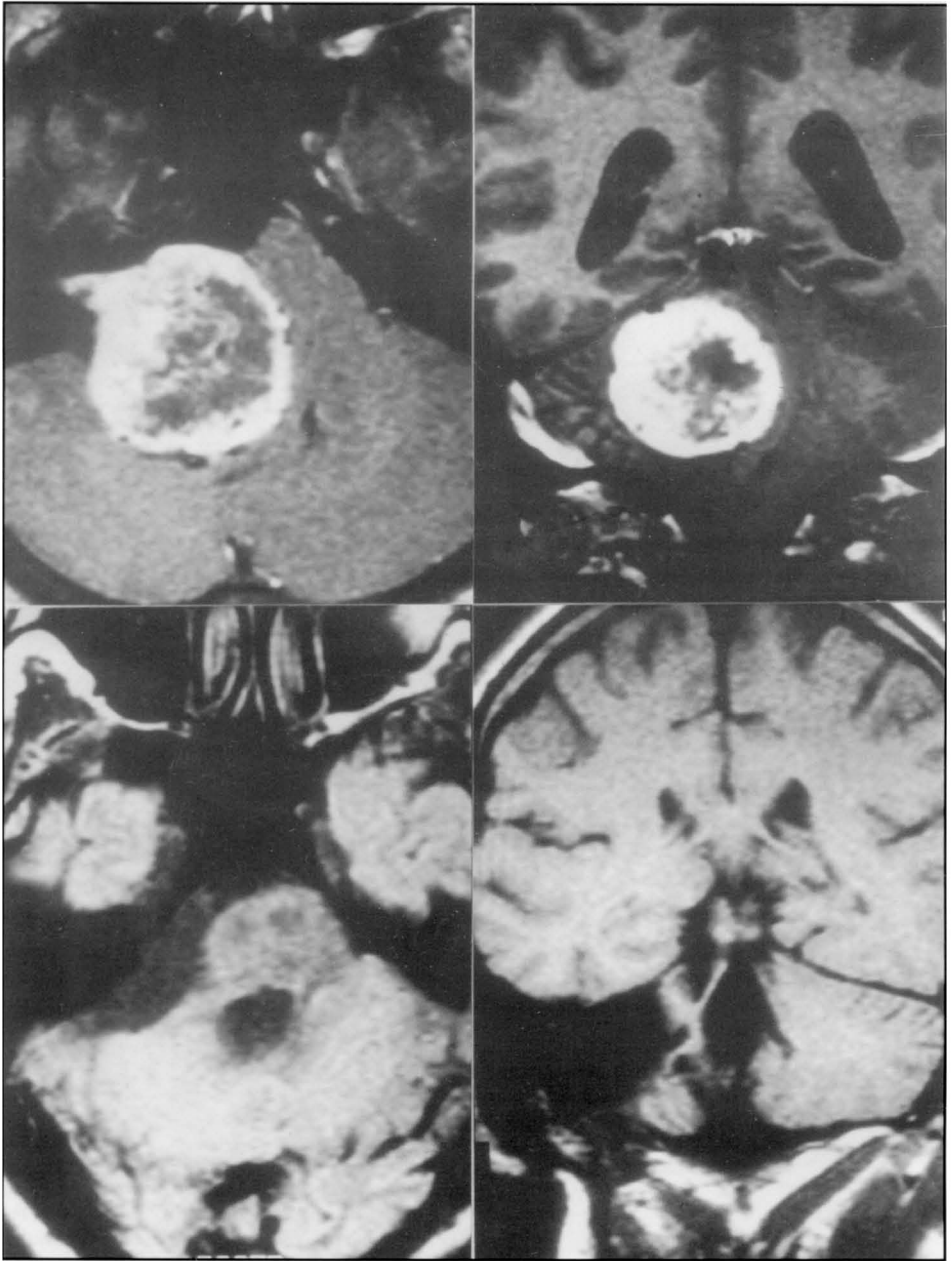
Upper: Preoperative MRI examinations (T1 with gadolinium) of a patient with a large acoustic neurinoma (4.5 cm) compressing the brain stem and the IV ventricle. Below: postoperative MRI (T1 with gadolinium) after total removal of the lesion and preservation of the facial nerve.
